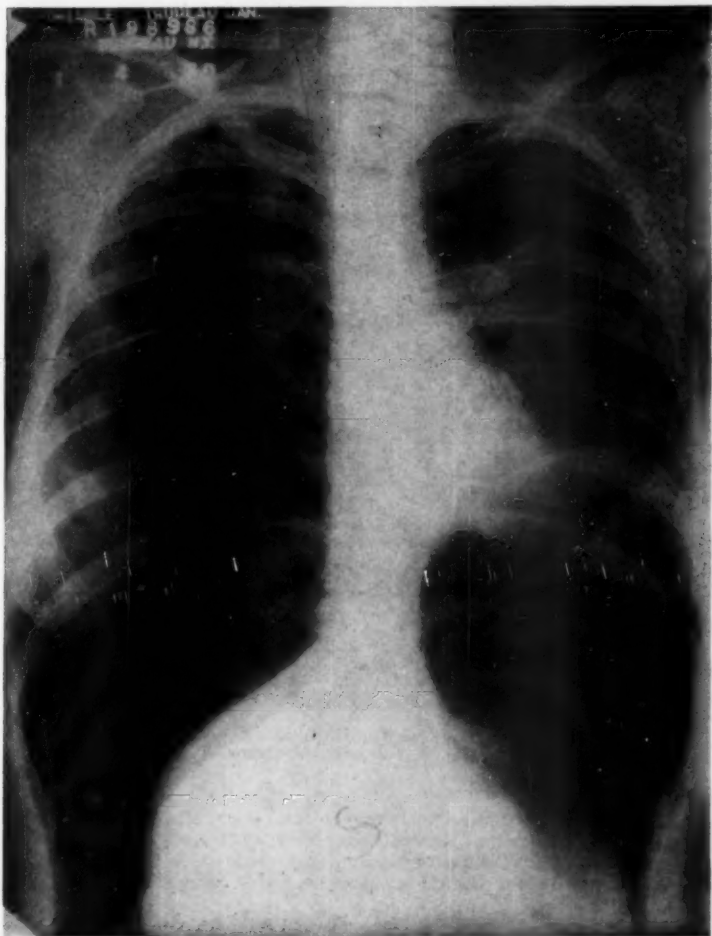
Chest roentgenogram taken January 4, 1950, showing a recent reactivation of disease and enlargement of cavity at the left root. Cavity still present at right apex. Pneumoperitonium.
